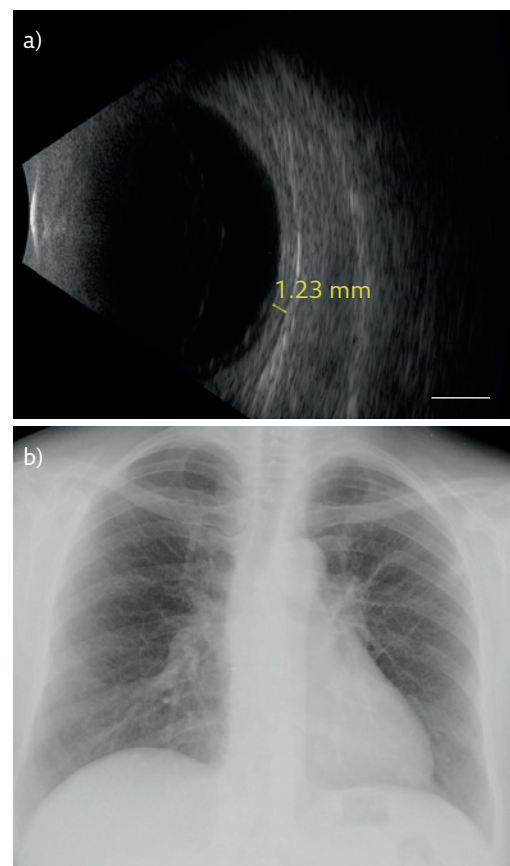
a) Ultrasound of the right eye after 5 months of crizotinib, with measurement showing regression of the choroidal metastasis. Scale bar=5 mm. Image from January 2019, courtesy of Z. Hendrickson, Clinic of Ophthalmology, 1st Medical Faculty of Charles University and General University Hospital, Prague, Czech Republic. b) Chest radiograph showing regression of the primary lung tumour after 4 months of crizotinib. Image from December 2018.
